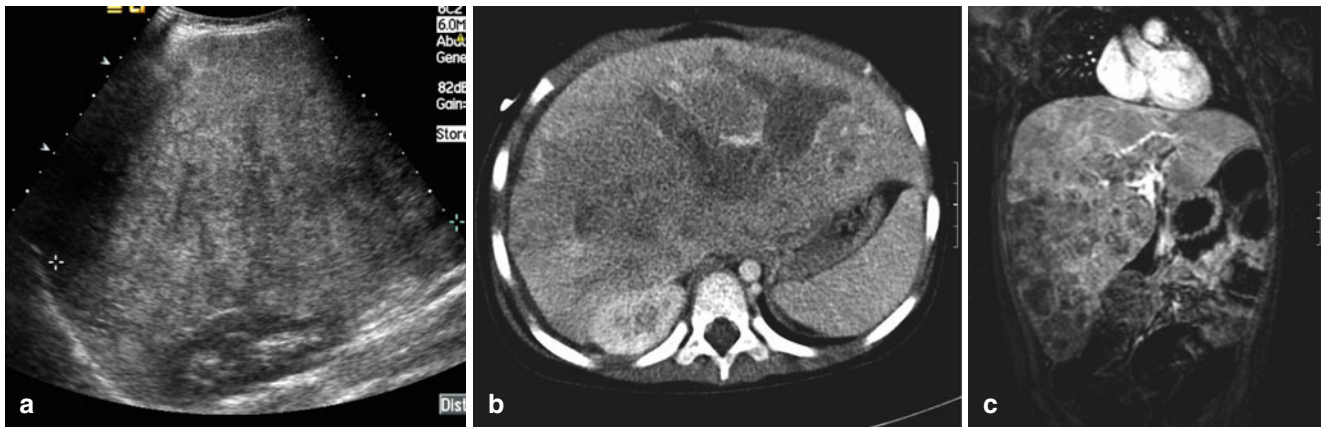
Hepatoblastoma. (a) Ultrasound shows extensive involvement of the liver which is enlarged. (b) CT shows a diffuse infiltrative pattern. (c) Coronal MR (T1 weighted post contrast) showing the extent of liver enlargement. Much of the left lobe is unaffected
